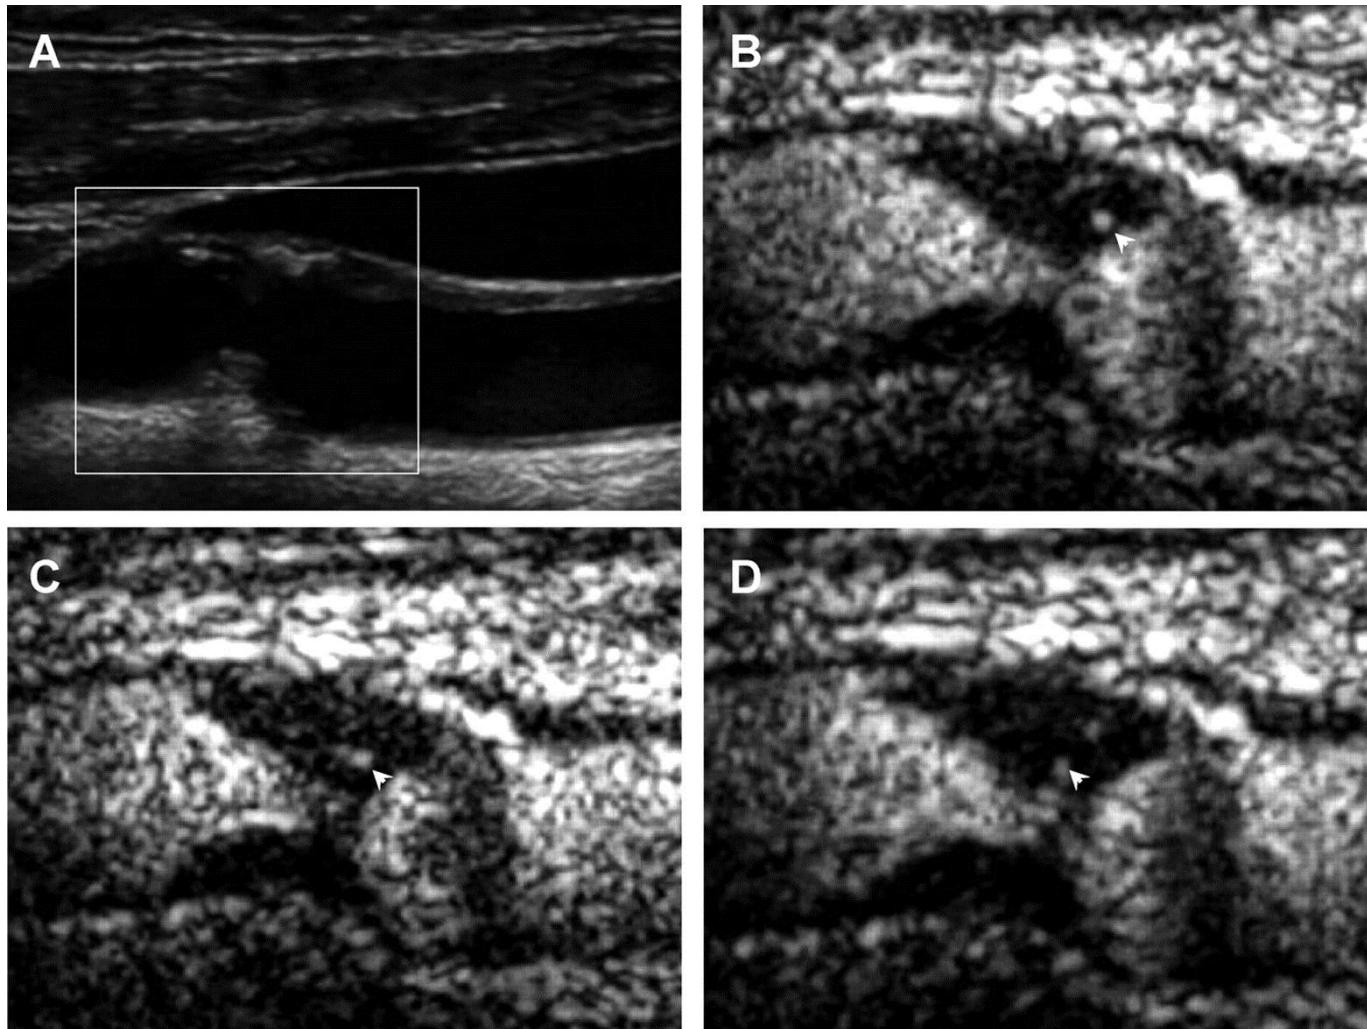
Carotid artery with intraplaque neovascularization grade 2 on contrast-enhanced ultrasound.
